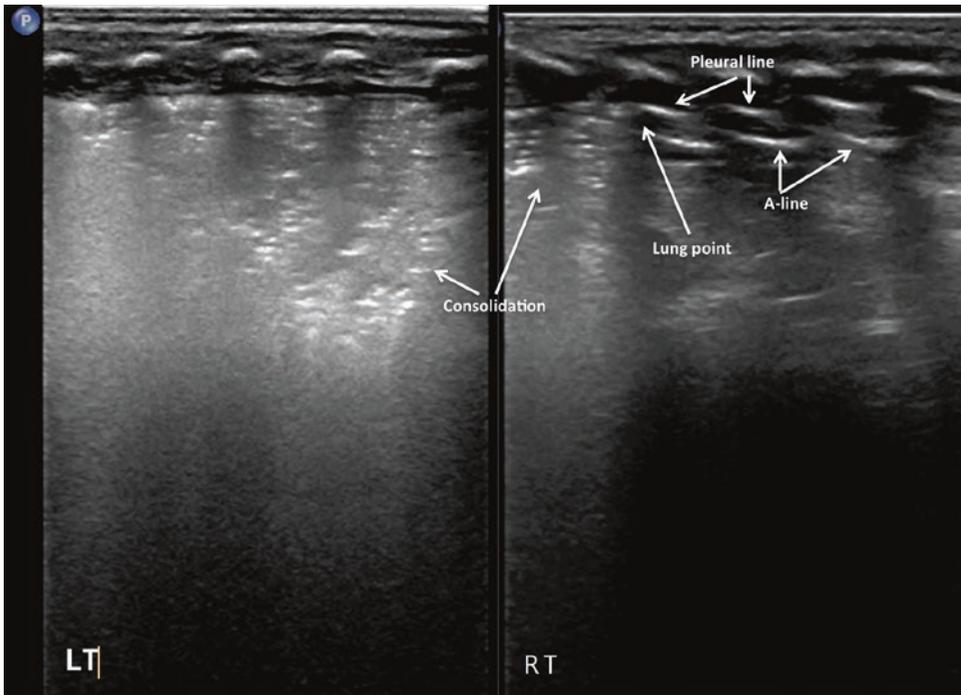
Ultrasonic manifestation of mild-moderate pneumothorax in a respiratory distress (RDS) patient. The infant had a GA of 37⁺⁶ weeks and was delivered by cesarean section with a birth weight of 2850 g. The infant was admitted to our NICU because of severe dyspnea for 32 h. The lung ultrasound showed a large area of lung consolidation with significant air bronchograms in the left lung
